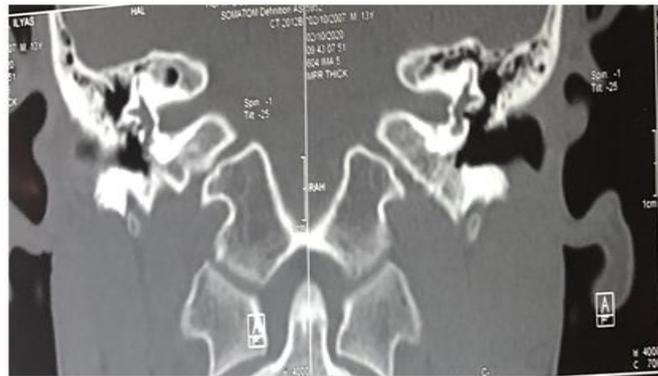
Axial & coronal temporal bone CT cut
